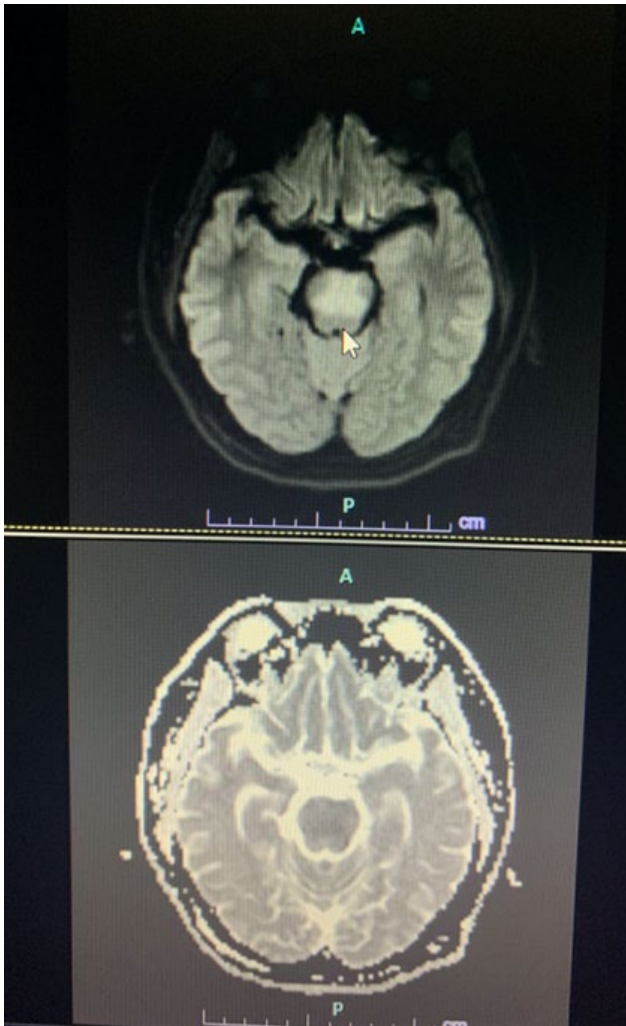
Fluid-Attenuated Inversion Recovery (FLAIR, above) and T2 (below) cranial MRI images, showing a prominent pontine hyperintense lesion (white arrow).
